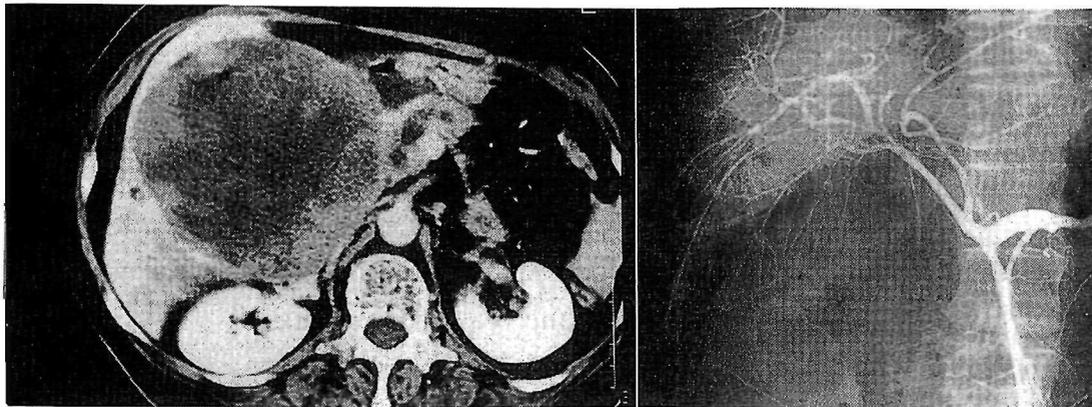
CT showing a large tumor with internal irregular areas of low attenuation (left) and hepatic arteriogram demonstrating the right hepatic arterial branches being stretched (right).
